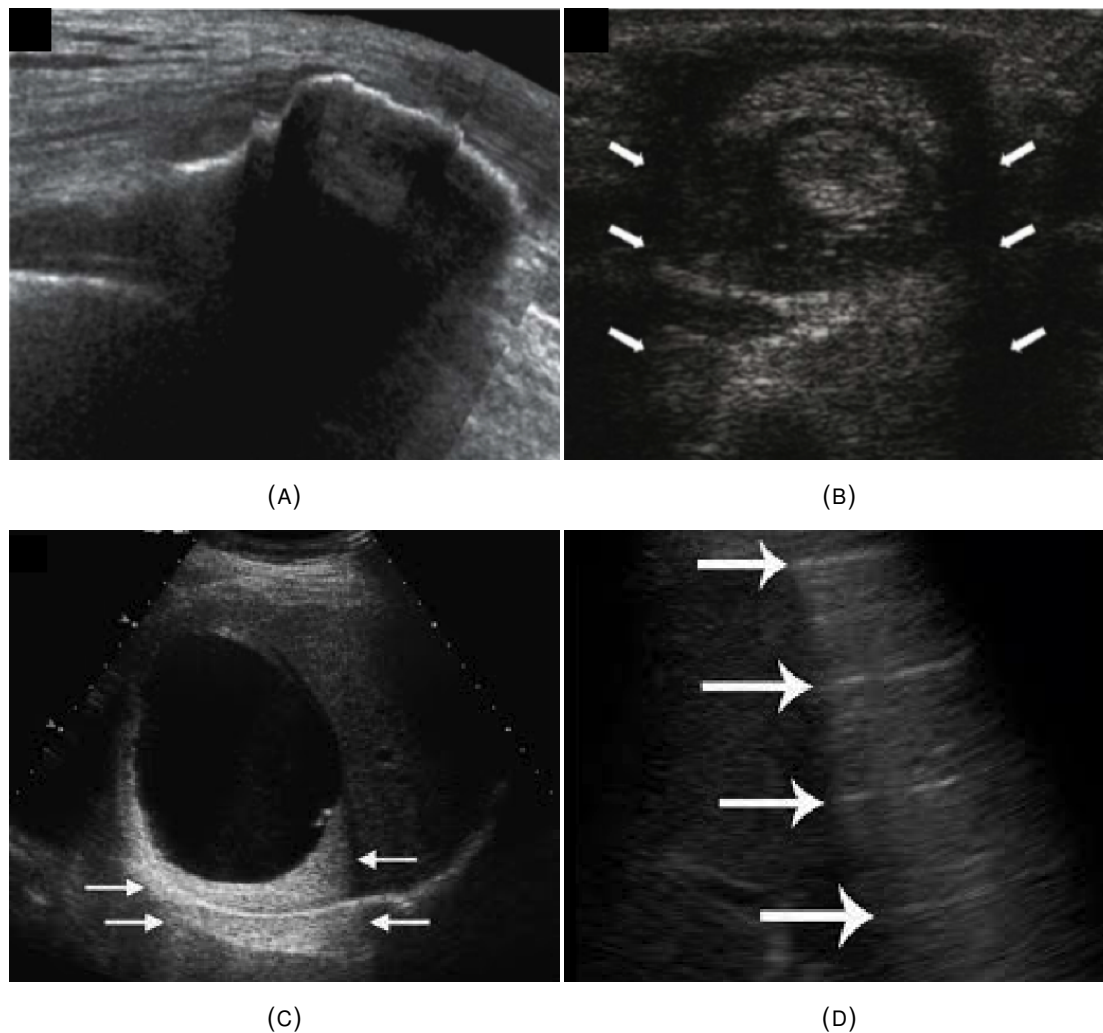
Examples of artifacts found in ultrasound images; A) acoustic shadowing on a patella - dark region; B) lateral acoustic shadowing on a finger extensor tendon - darker regions pointed by the arrows; C) posterior acoustic enhancement - brighter region pointed by the arrows; D) reverberation - successive parallel lines. Adapted from [19].
